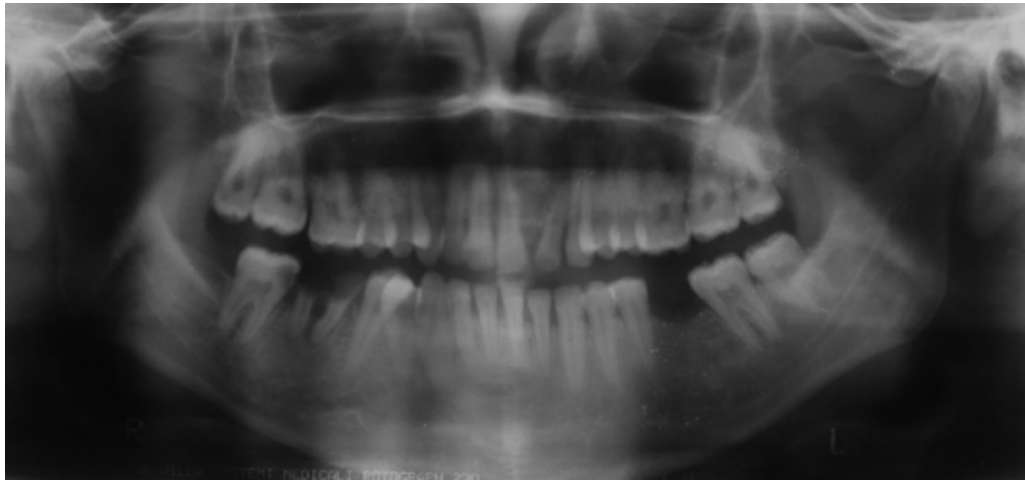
Panoramic radiograph revealed a well circumscribed unilocular radiolucency involving 21-22 region displacing 21 and 22. Radiolucency was ovoid in shape with a radiopaque border.
